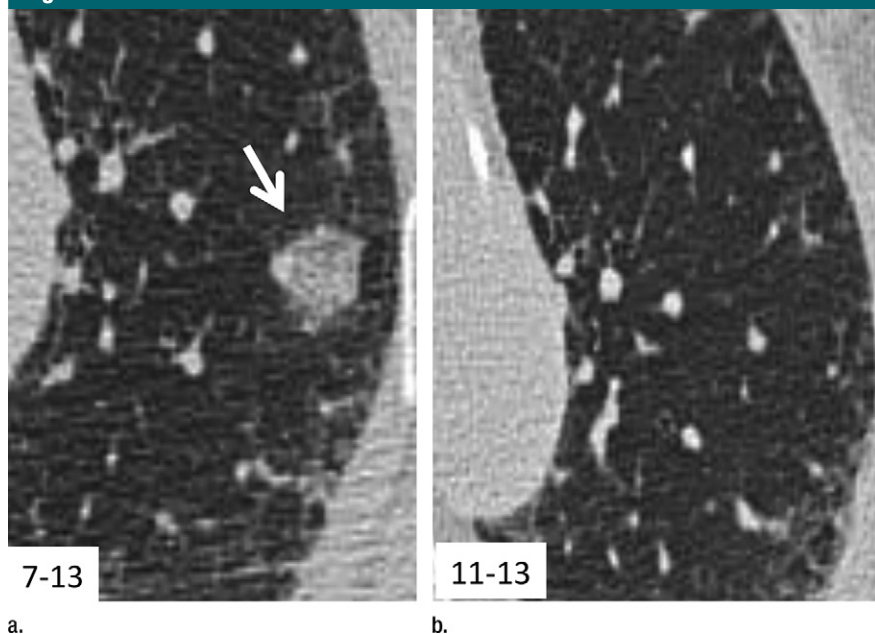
(a) Transverse 1-mm CT section through the left upper lobe shows an indeterminate 10-mm ground-glass nodule (arrow). (b) Follow-up CT image after 4 months shows interval resolution without treatment, consistent with a benign cause, such as focal infection.
